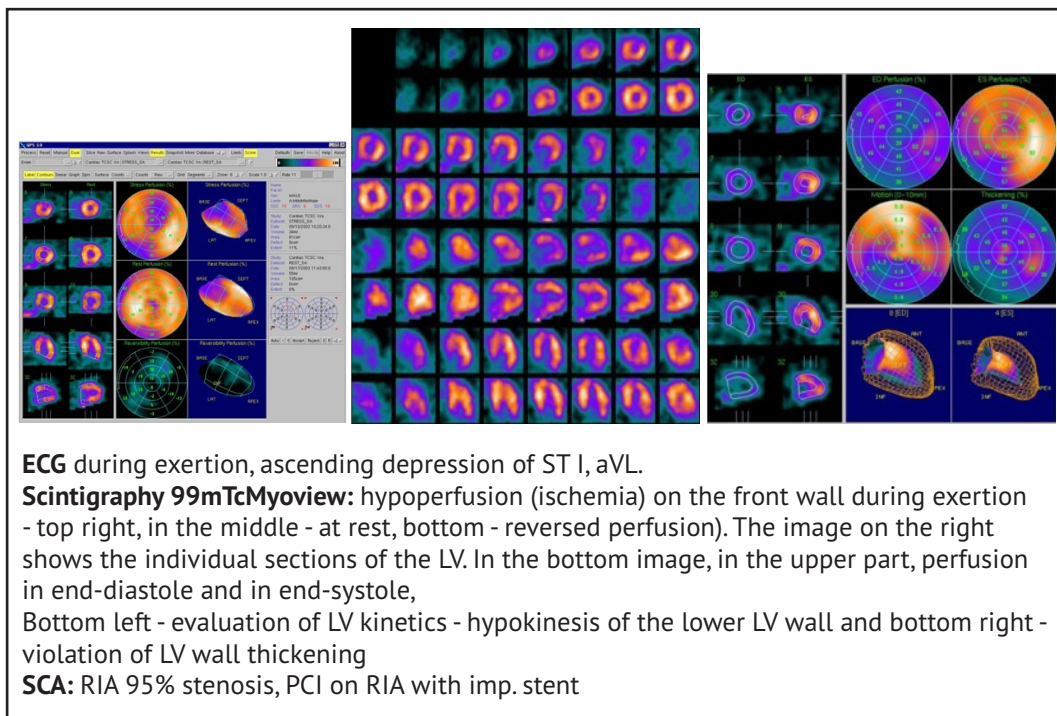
Positive scintigraphic finding in a diabetic- left above after exertion, below at rest, with signs of silent ischemia on the side wall.
